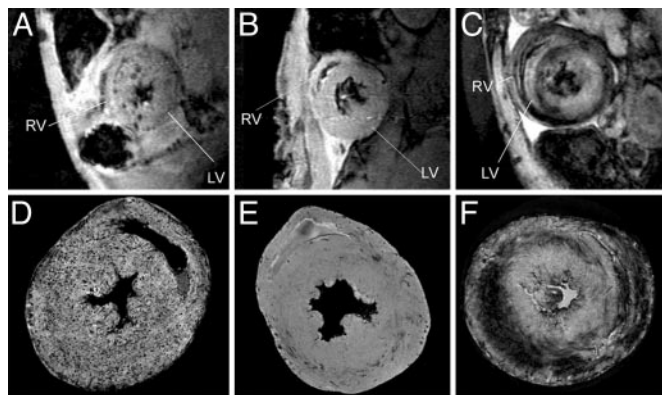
Contrast patterns labeled with two different contrast agents. (A–C) *In vivo* MRI of macrophage accumulation on POD 6 of an allograft heart with MPIO-particle labeling (A), an isograft heart with MPIO-particle labeling (B), and an allograft heart with USPIO labeling (C), with 156- μm in-plane resolution at 4.7 Tesla. (D–F) MRM at 11.7 Tesla using a Bruker AVANCE-DBX MRI instrument with in-plane resolution of 40 μm of an allograft heart with MPIO-particle labeling (D), an isograft heart (E), and an allograft heart with USPIO labeling (F). All hearts used in the *in vivo* and *ex vivo* measurements were the same ones except those used in A and D.
